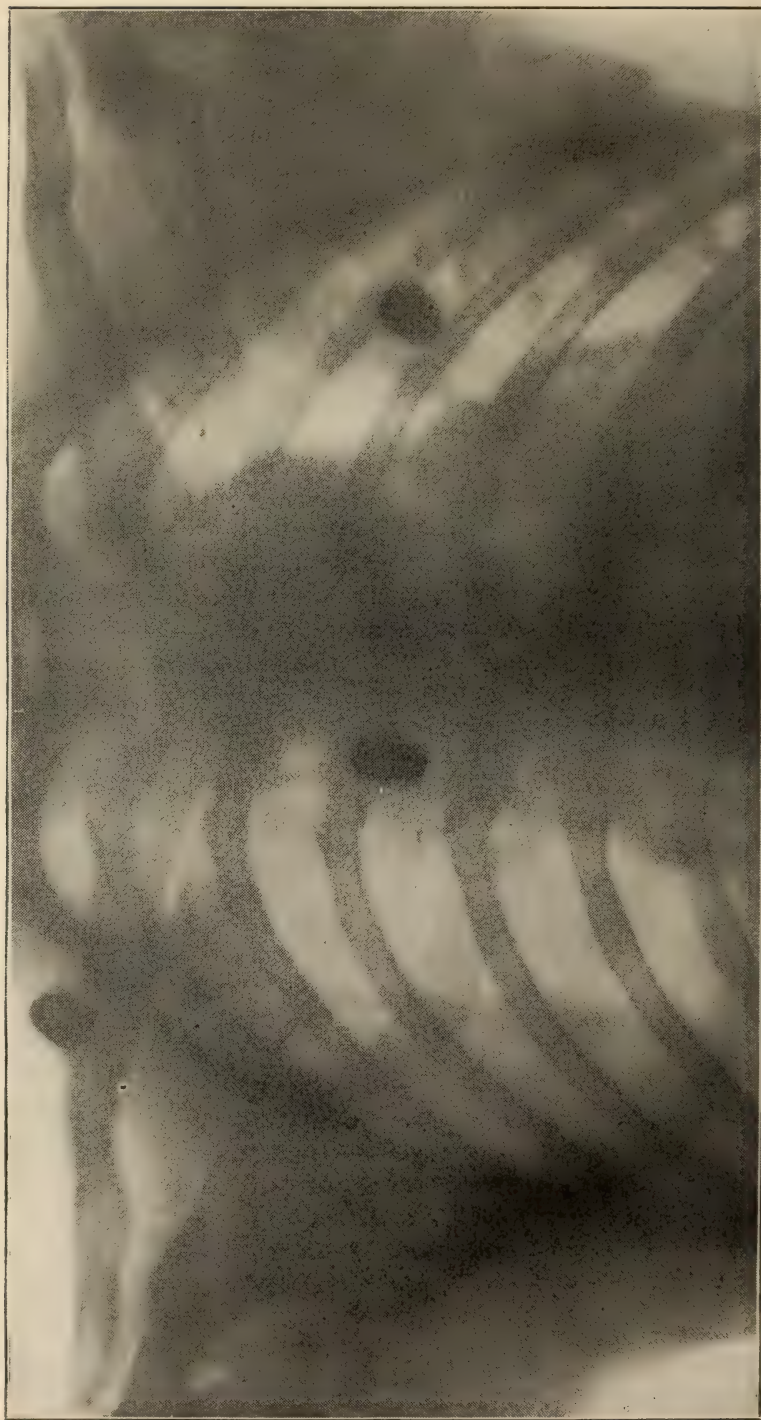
RADIOGRAPH SHOWING LOCATION OF BULLETS IN CHEST.
